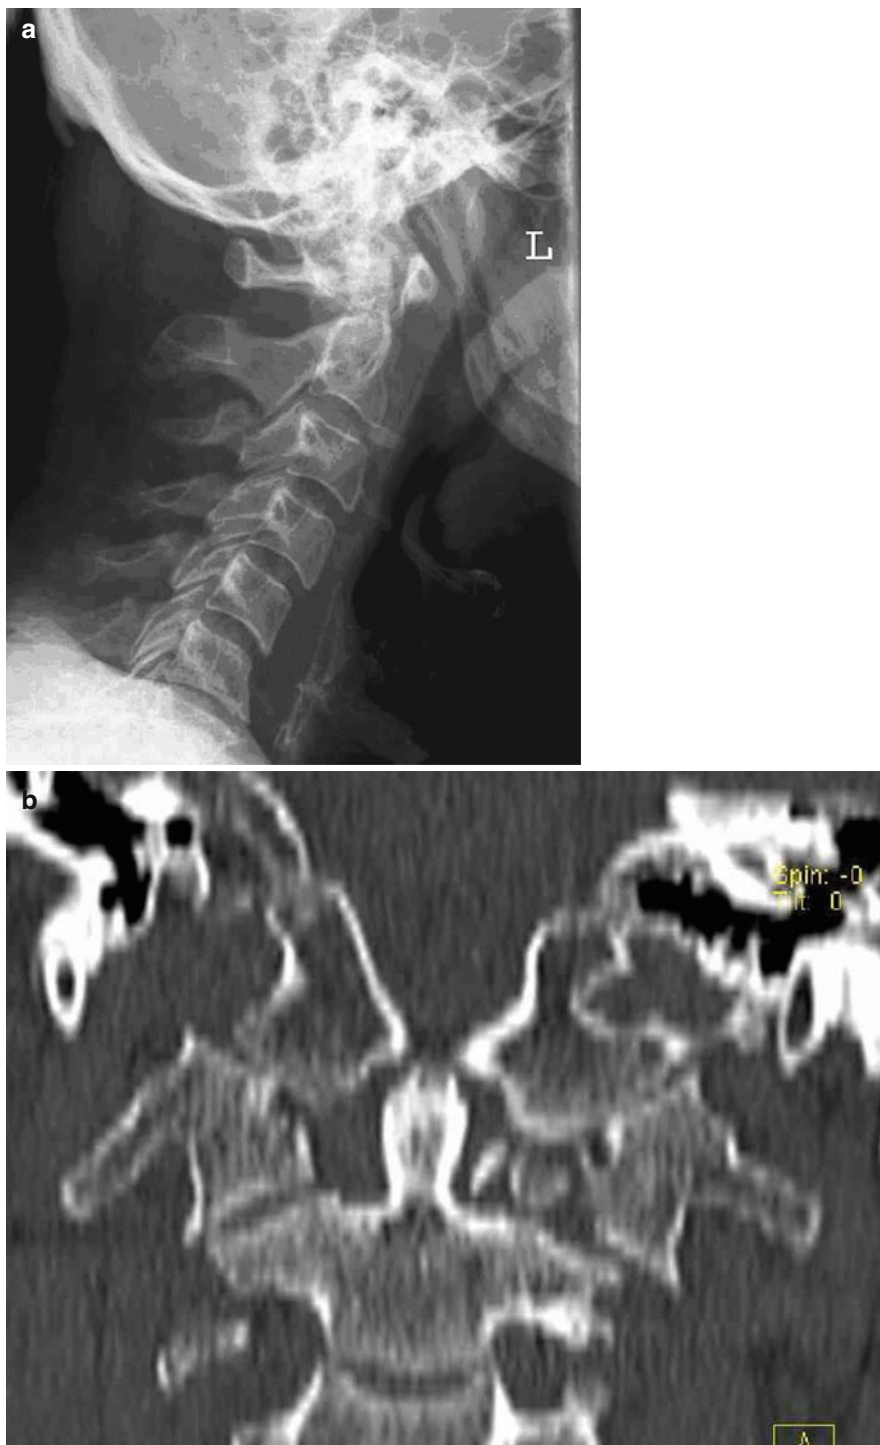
Fifty-two-year-old patient with a Gehweiler type-III fracture, preoperative X-ray, CT, and postoperative X-rays of the posterior C0–C3 stabilization
